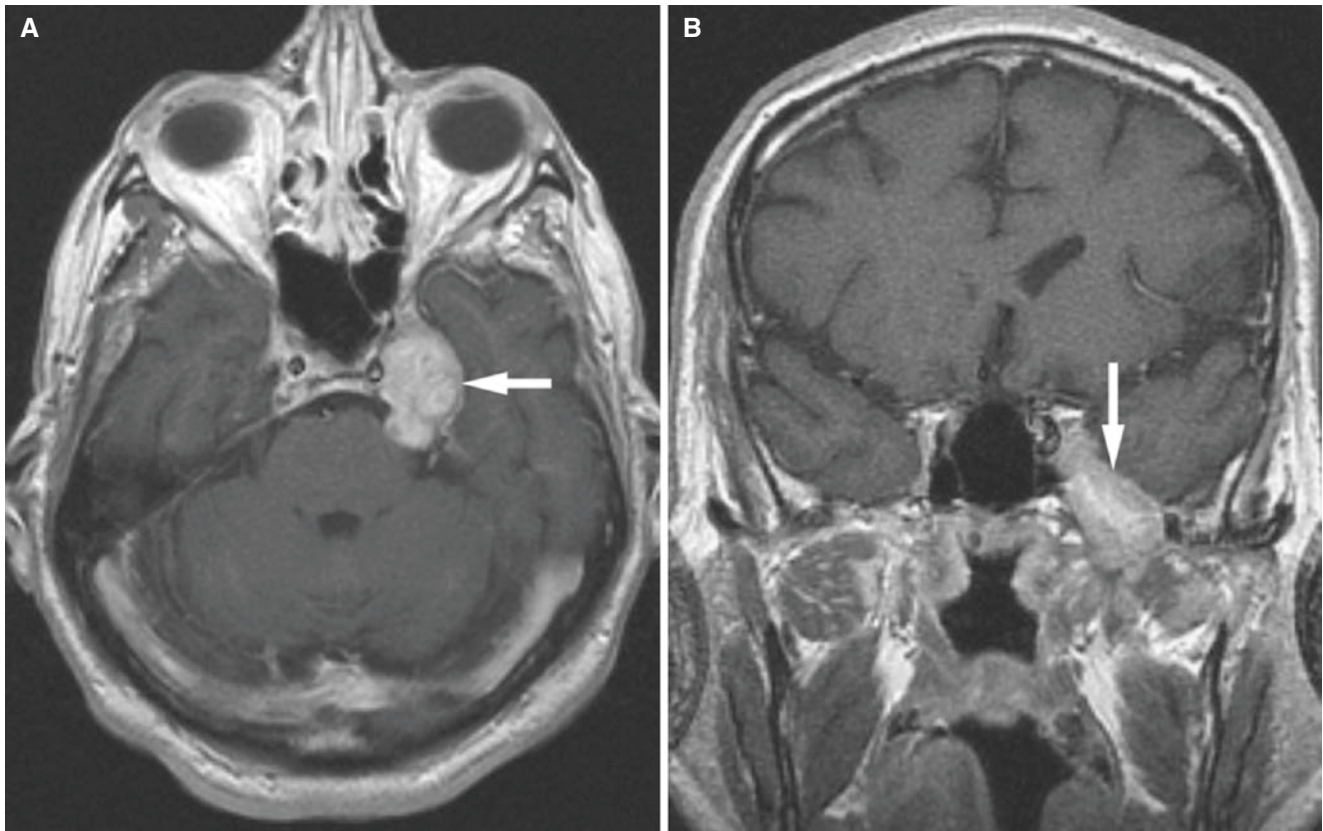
Trigeminal schwannoma; 70-year-old male with memory loss and seizures. (A) Axial T1-weighted post-Gd MRI shows enlarged mass (arrow) in wall of left cavernous sinus. (B) Coronal T1-weighted post-Gd MRI shows mass extending through the foramen ovale (arrow)
